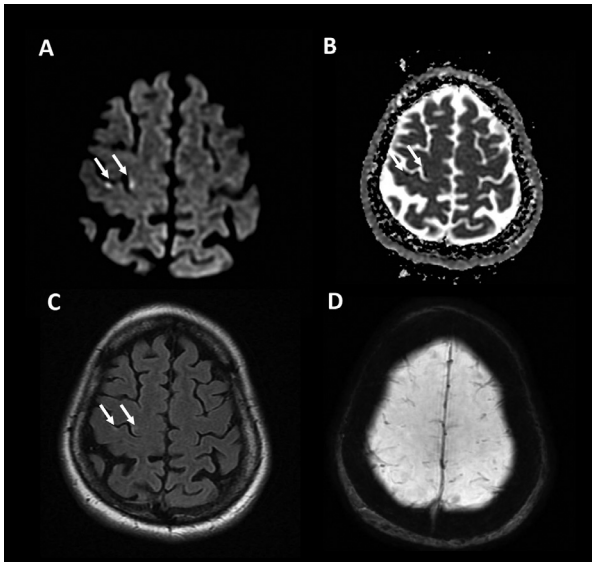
An axial section of diffusion-weighted (Panel A), Apparent diffusion coefficient (ADC) (Panel B), Fluid attenuation inversion recovery (FLAIR) (Panel C) and Susceptibility-weighted Angiography (SWAN) (Panel D) images of the brain shows two small acute brain infarctions (arrows) in right perirolandic cortex without signs of previous ischemic lesions and hemorrhagic infarction.
